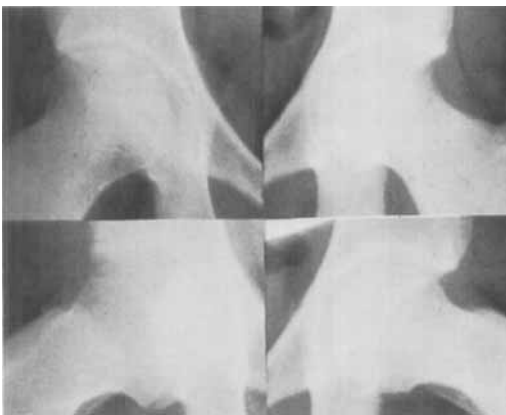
Case 4. Age 14. Radiograph of the child's hips demonstrating persistent coxa magna on the right side.
